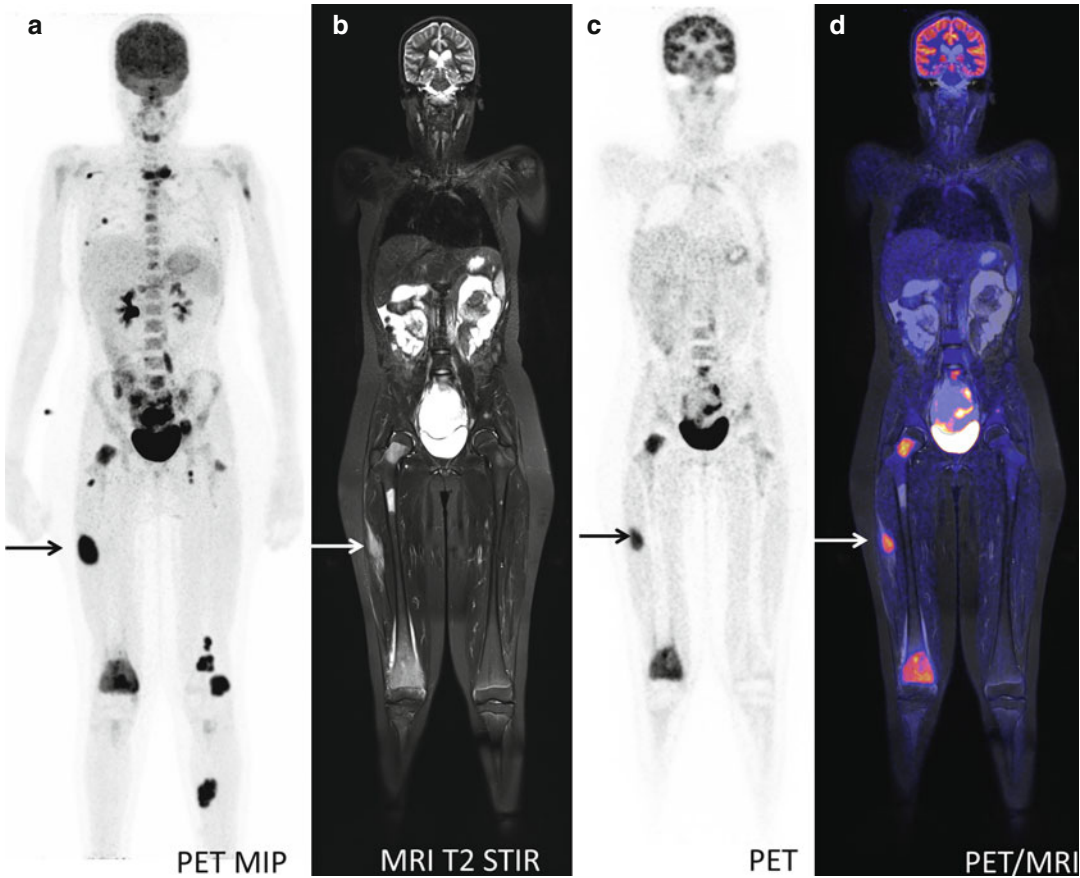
A 13-year-old girl with neurological symptoms and pain in the right knee. FDG-PET for suspected infectious disease: (a) PET MIP demonstrates widespread foci of FDG-accumulation suspected for disseminated
